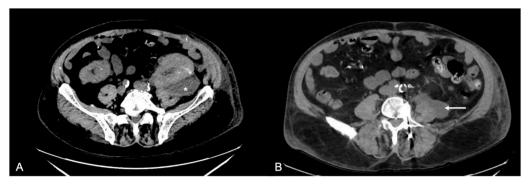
CT Abdomen and Pelvis demonstrating left perinephric donor kidney fluid collection (A) as marked with an asterisk and a left Psoas muscle abscess (B) as marked with an arrow.
